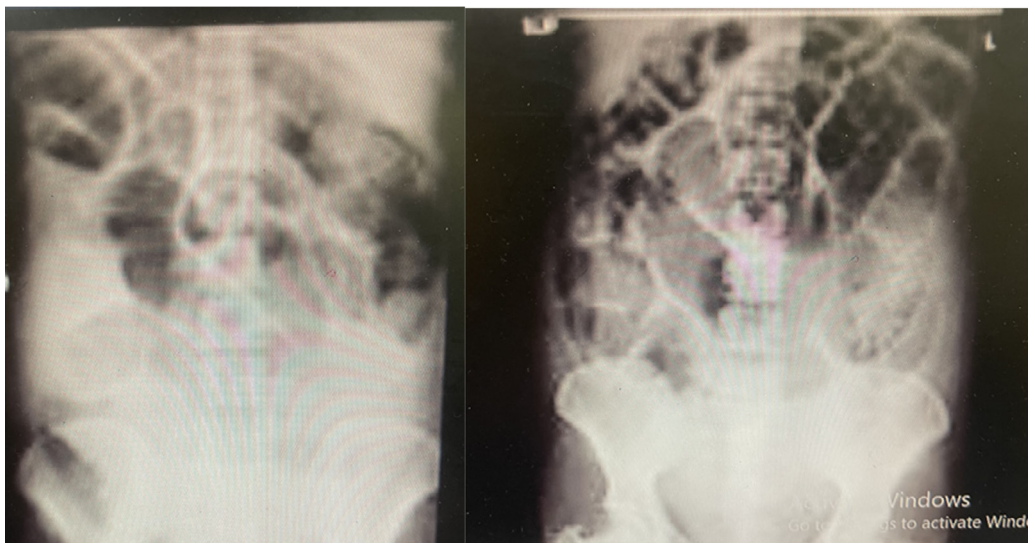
left: the first post ileus abdominal X-ray revealed small bowel and colon dilatation. right: abdominal X-ray on the exploratory laparotomy revealed exacerbation.
